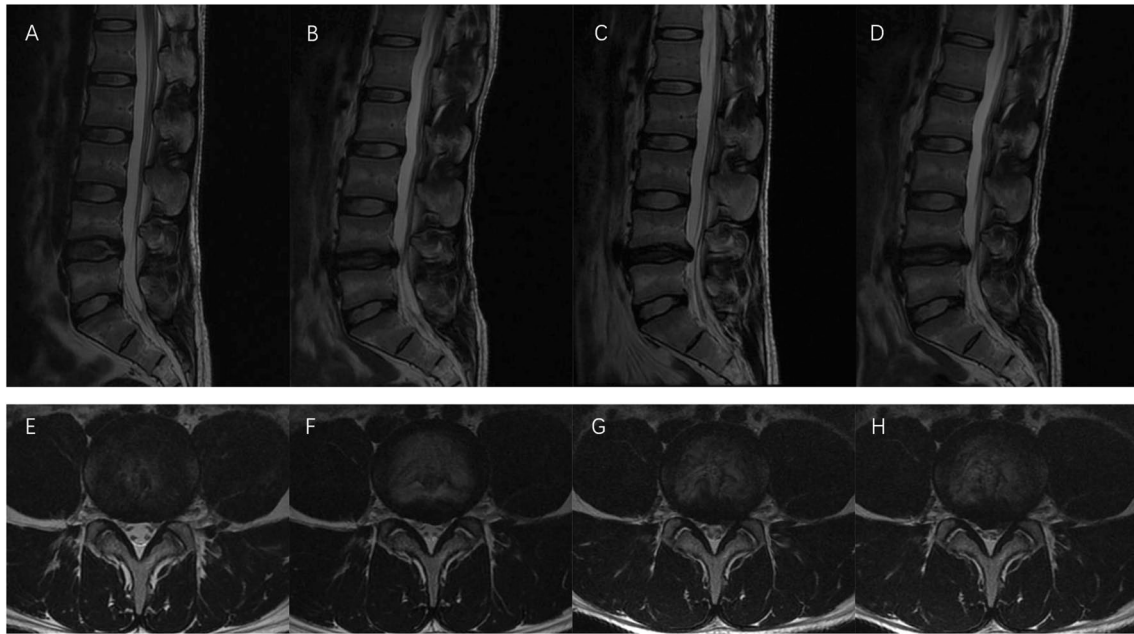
A 34-year-old man. Sagittal T2-weighted fast recovery fast spin-echo (FRFSE) (A, B, C, D) and axial T2-weighted FRFSE of (E, F, G, H) of rMRL (A, E), eMRI (B, F), r+alMRI (C, G) and e+alMRI (D, H). Relative to rMRI, spinal stenosis in L4-5 aggravated progressively in the other three examinations. DSCA was
